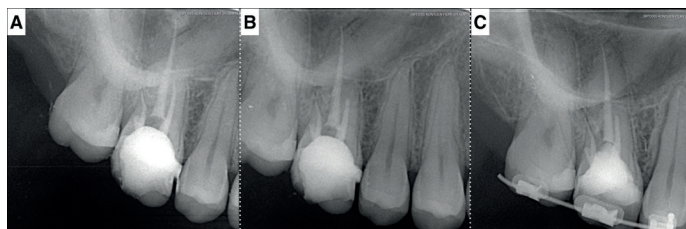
A, Periapical X-ray after orthograde canal grafting with calcium silicate cement, B: post-operative X-ray after surgery, C: two-year follow-up X-ray
